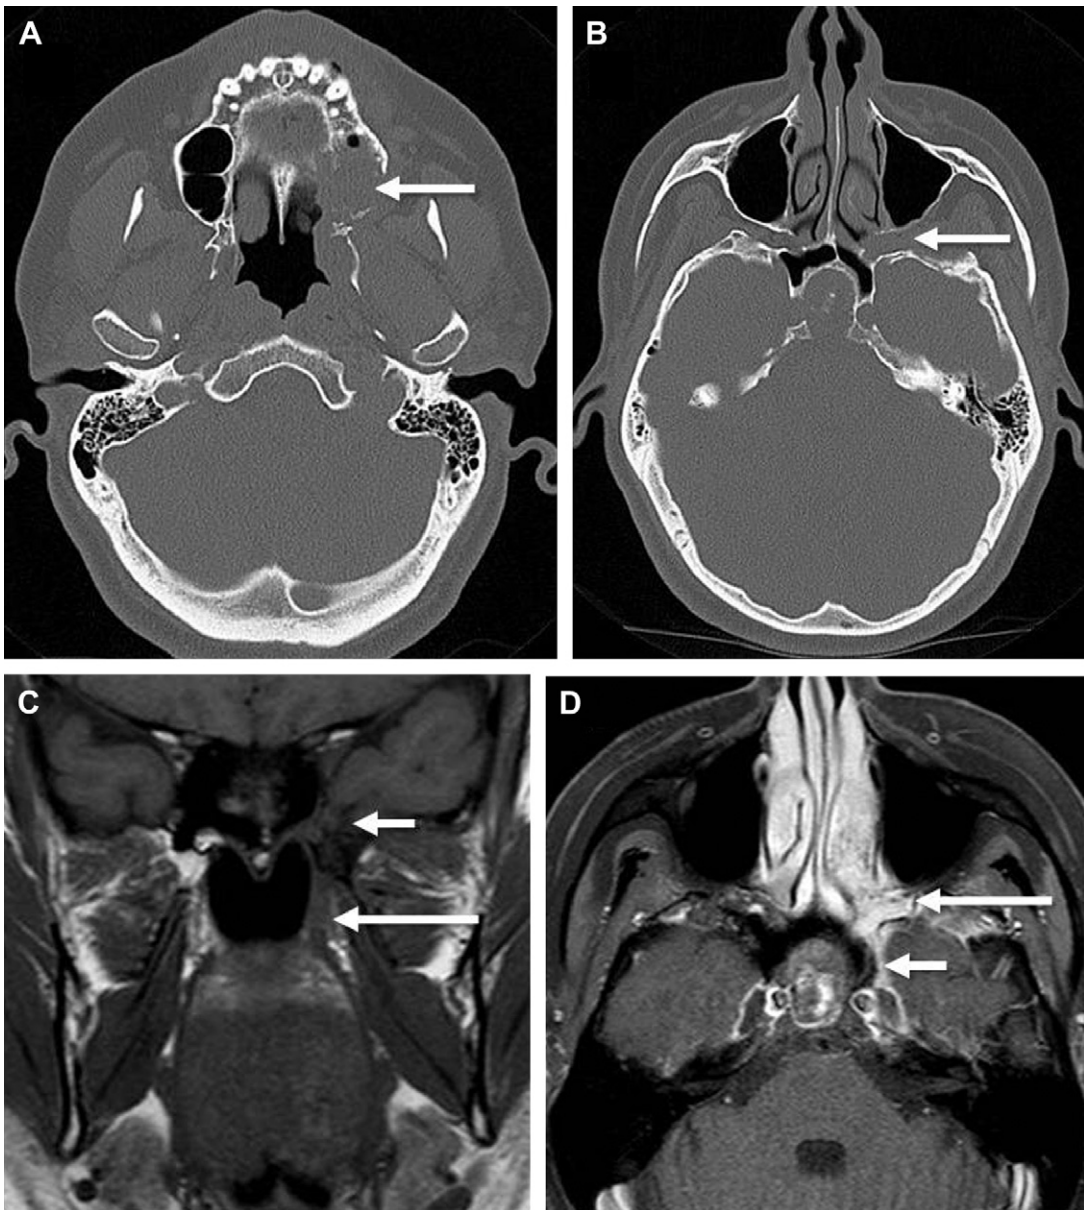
Perineural tumor extension. (A) Axial CT bone windows shows a destructive process (*arrow*) in the left maxillary alveolar ridge in this patient with an adenoid cystic carcinoma of the palate. (B) Widening of the left pterygopalatine fossa (PPF) is seen (*arrow*). (C) Coronal T1-weighted image shows abnormal T1 hypointense soft tissue replacing the PPF (*long arrow*) and foramen rotundum (*short arrow*). (D) Axial postcontrast fat-saturated T1-weighted image confirms abnormal enhancement of the tissue in the PPF (*long arrow*) and foramen rotundum (*short arrow*).
